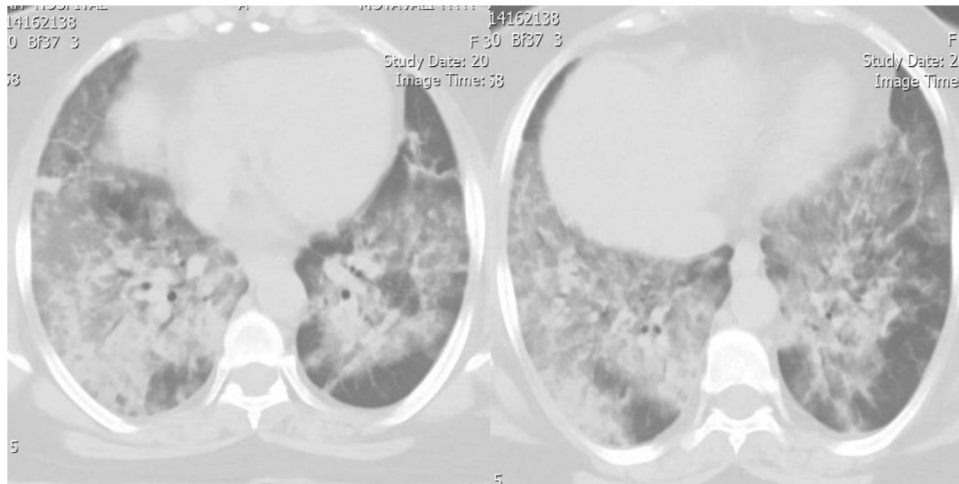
First day of admission. The CT scan showed only diffused lung consolidations.
